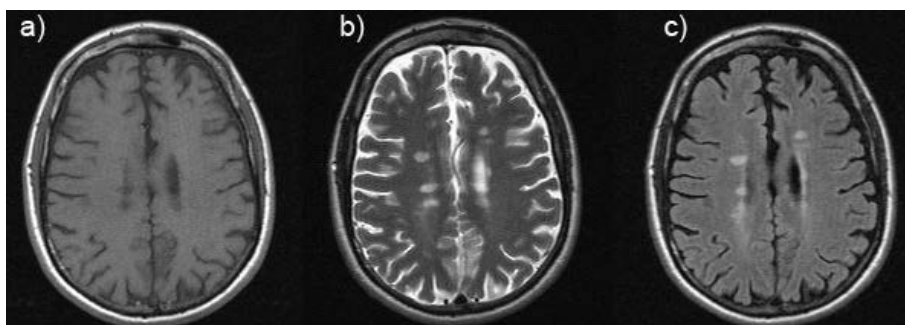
Example of clinical standard MRI used for monitoring MS (obtained in our laboratory). a) T1-weighted image, b) T2-weighted image, c) FLAIR.
